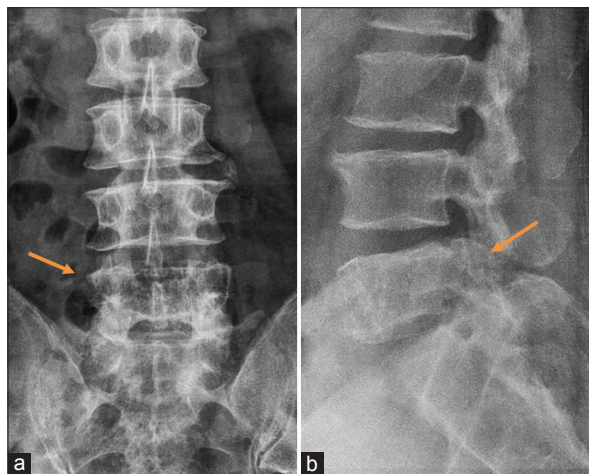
Antero-posterior (a) and lateral (b) X-ray of the lumbosacral spine showing an L5 irregular body with structural trabecular alteration
